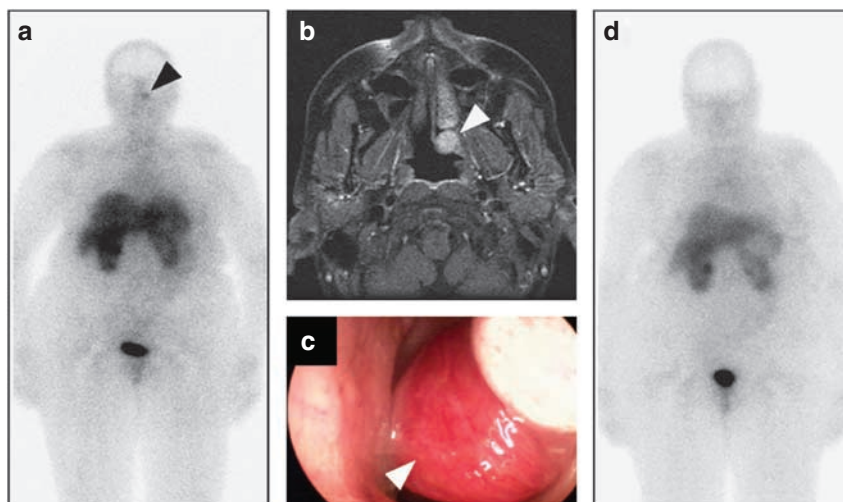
Radiographic and macroscopic findings. (a) ^{111}In -octreotide scintigraphy 3 months before surgery, demonstrating a focus of enhanced inappropriate uptake slightly to the left of the midline of the head (arrow). (b) Magnetic resonance imaging of the head shows a $1.5 \times 1.4 \times 1.4$ cm rounded mass (arrow) within the dorsal aspect of the left nasal cavity. (c) Macroscopic image of the very vascular tumor *in situ*, just before surgical removal. (d) ^{111}In -octreotide scintigraphy 5 months post-surgery, demonstrating lack of tracer uptake in the former location of the tumor.
